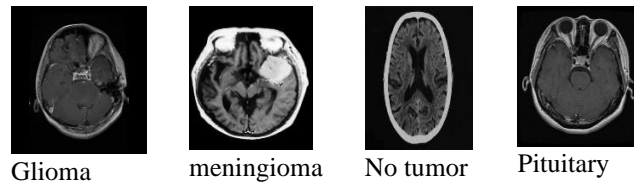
Samples of brain tumor MRI dataset a. glioma b. meningioma c. no tumor d. pituitary
